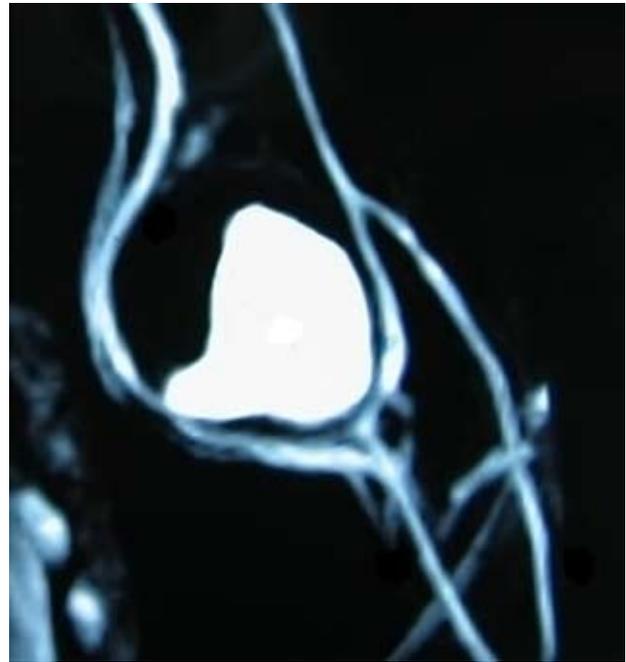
Helical contrast computed tomography. Three-dimensional reconstruction of a brachial aneurysm at the elbow level.
